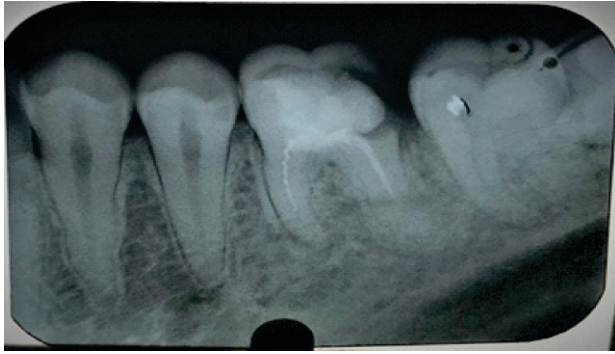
Pre Operative Periapical Radiographic Image
